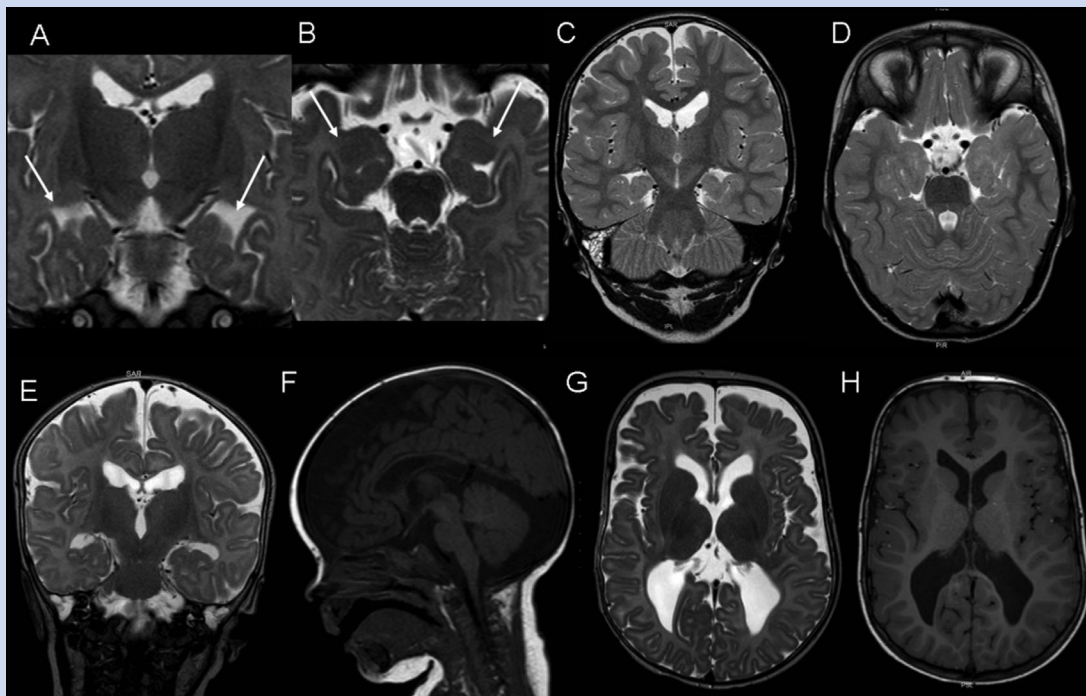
Brain MRI in a patient with *FGFR3* mutation-verified hypochondroplasia. T2-weighted coronal and axial slices (A,B at age 4 months and C,D at 3 years 4 months) show symmetric bilateral temporal lobe dysgenesis (arrows) with abnormally shaped temporal horns, and aberrant hippocampal configuration with poorly formed and abnormally oriented anterior parahippocampal gyri and vertical orientation of the collateral sulci. The patient had also squared anterior horns of the lateral ventricles (C) and abnormal white matter T2 hyperintensity and poor gray–white matter differentiation in anterior and mesial temporal lobes (D). Another *FGFR3* mutation verified patient had a similar temporal lobe dysgenesis (E; T2-weighted coronal image at age 7 months) and abnormal anterior and mesial temporal lobe white matter signal intensity (not shown) but also mild callosal dysgenesis with a small splenium and thinning of corpus callosum, and an arachnoid cyst in the posterior fossa (F; T1-weighted sagittal image at age 7 months). The lateral ventricles were squared and enlarged and peritrigonal white matter was reduced (G; T2-weighted axial image at age 7 months and H; T1-weighted axial image at age 3 years).
